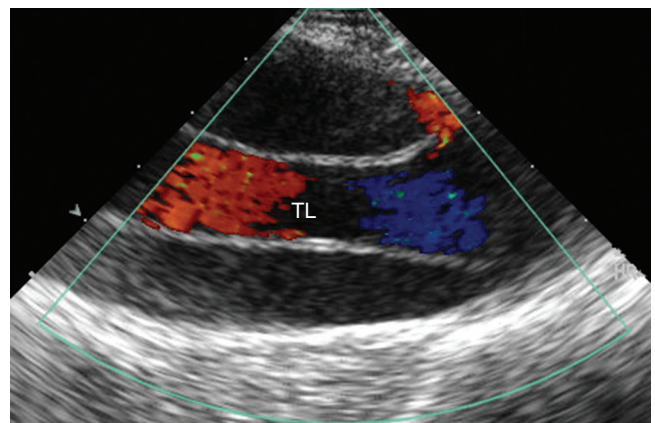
■ A dissection flap is seen within an enlarged aorta, imaged by transesophageal echocardiography. The true lumen (TL) is visualized with color Doppler imaging.
